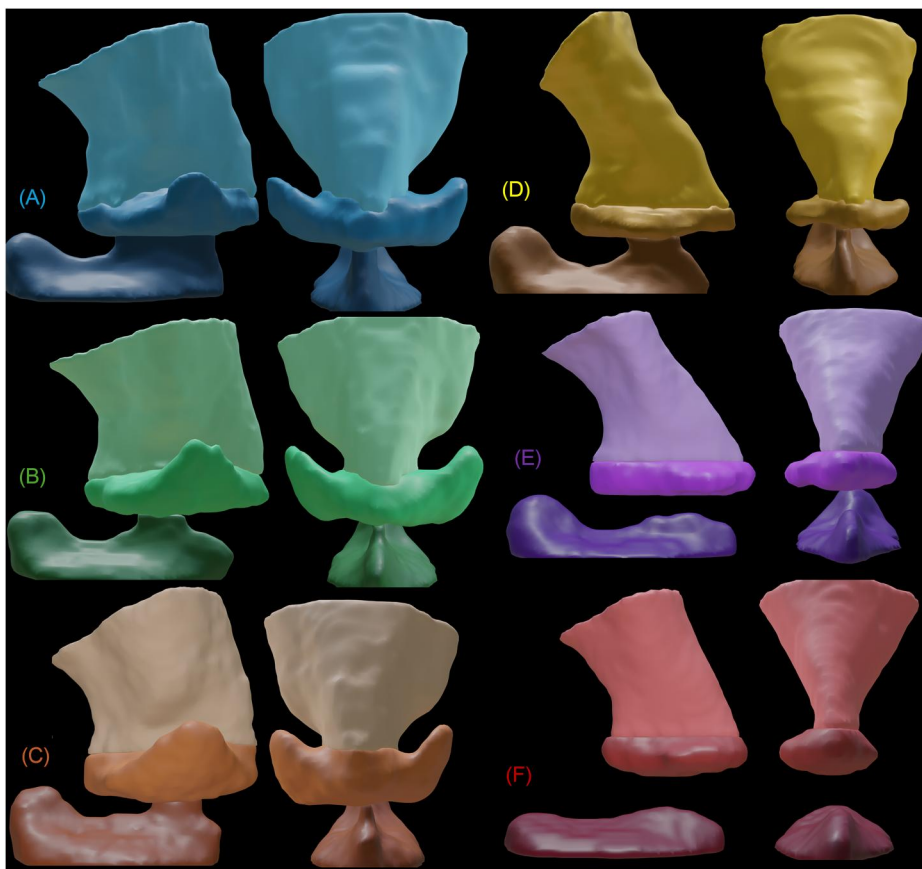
Three-dimensional reconstructions of vocal tract segmentations derived from 3D VF MRI. Each model comprises three anatomically defined sub-volumes: the laryngeal vestibule (superior), the laryngeal ventricle (middle), and the subglottal space (inferior), rendered in matching hue gradations for each phonation type. Left, lateral view; right, anterior view. The phonation types are color coded in *Stiff* (blue), *Thin* (green), *Thick & VenF retract* (orange), *Thick* (yellow), *Thick & AES narrow* (violet), *Thick & VenF constrict* (red).
